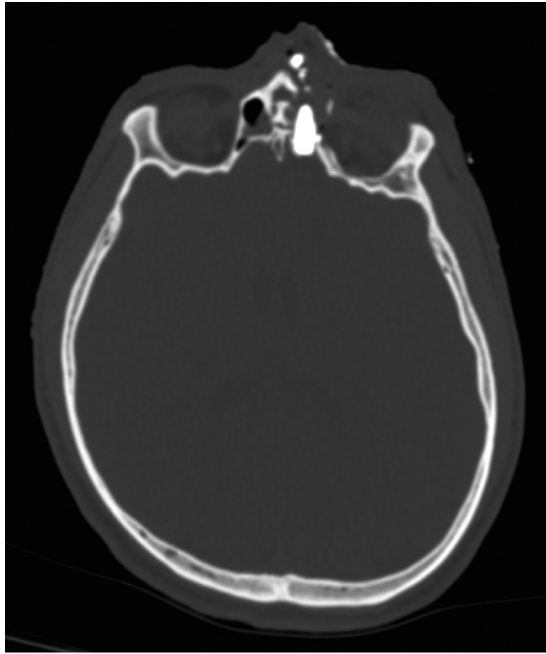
Computed tomographic scan of the face showing a retained 7.62 mm high velocity rifle bullet within the left ethmoid sinus.
